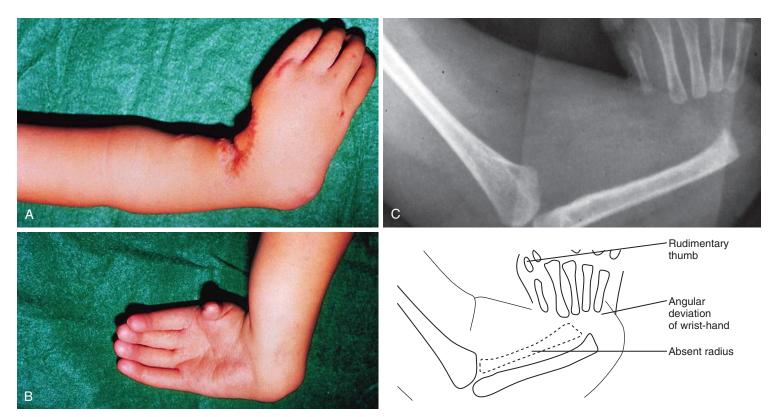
Radial club hand. A, The forearm is shortened with radial deviation of the hand and wrist on the ulna. B, A flexion deformity of the hand and wrist on the forearm and a hypoplastic thumb are present. C, Radiograph shows absence of the radius, dislocation of the carpus, and a rudimentary thumb, all characteristic of radial club hand. (*Clinical photographs courtesy Joseph Imbriglia, MD, Allegheny General Hospital, Pittsburgh, Pitsburgh, Pa.*)
